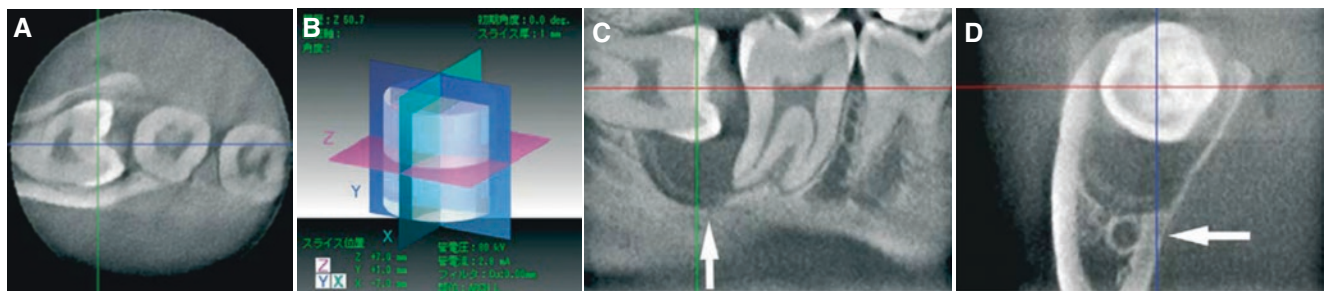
Follicular cyst, mandible; 38-year-old patient with incidental finding. (A) Axial image shows radiolucency around crown of horizontally impacted wisdom tooth with thinning of the lingual cortical plate but no bony expansion. (B) Three image planes indicated by different colors. (C) Sagittal CBCT image shows pericoronal radiolucency
